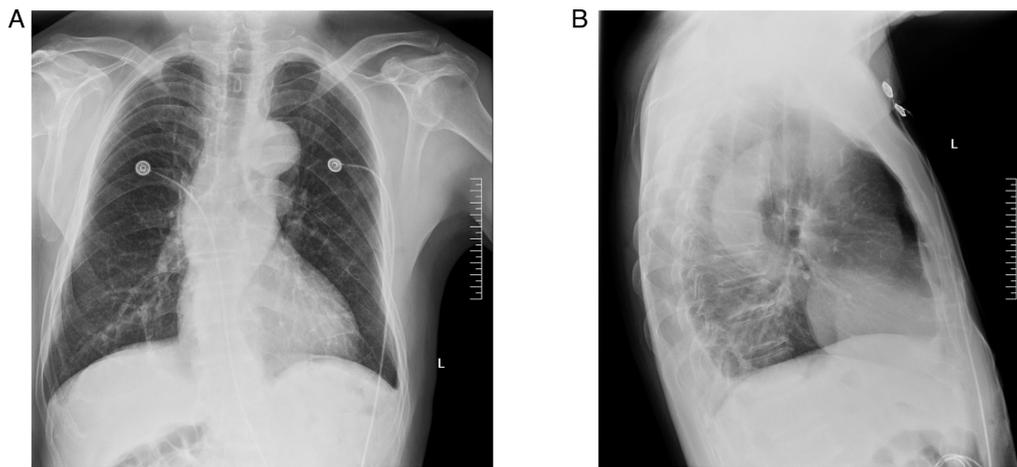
X-ray performed in May 2021. (A) Anteroposterior film, after thoracoscopic mediastinal lesion resection, clear lung fields with no substantial lesions were observed in both lungs. (B) Lateral film, no obvious abnormality in the lungs.
